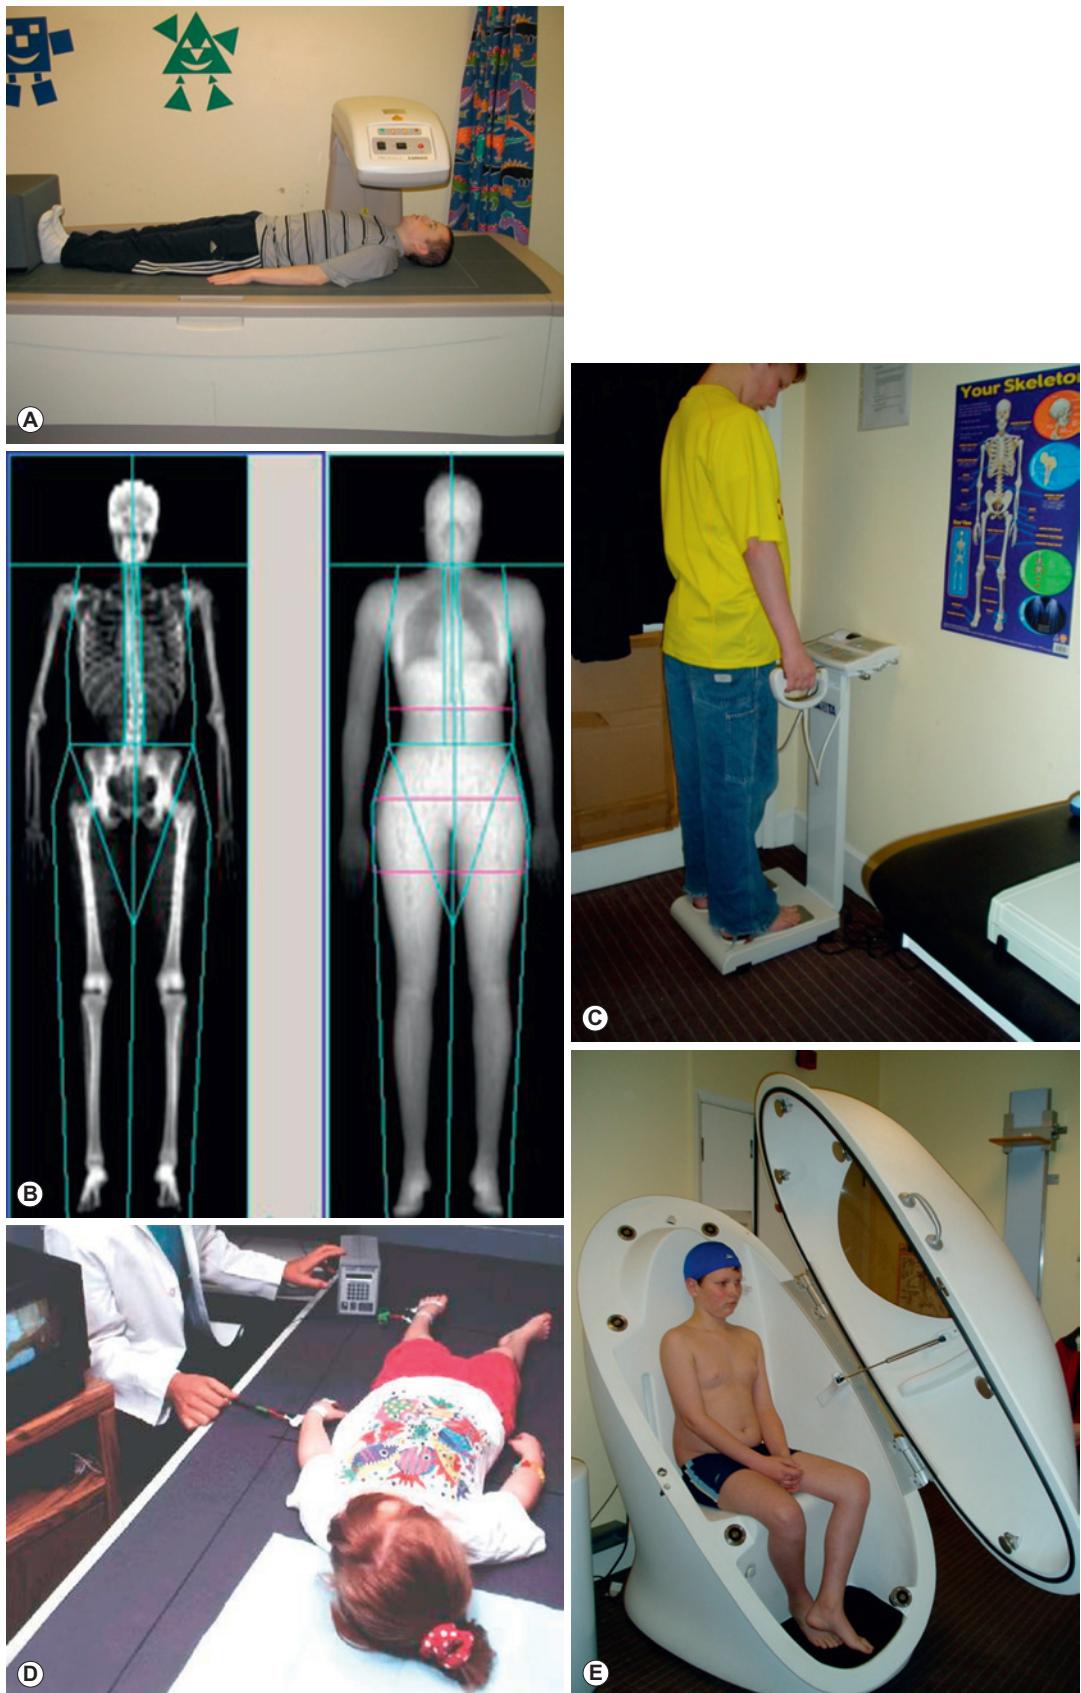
Some techniques used to measure body composition in children. A,B. Child undergoing a dual energy X-ray absorptiometry (DXA) whole body scan and the image generated. C,D. Children undergoing bioelectric impedance analysis measurements with two types of machine (standing and supine). E. Air displacement plethysmography (BodPod), used to measure body volume by air displacement plethysmography.
